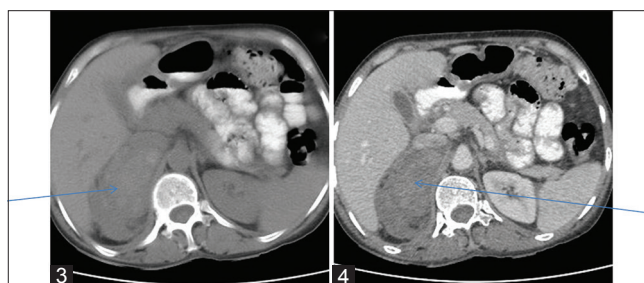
(3) Transverse section plain CT-enlarged right adrenal gland with ill-defined hyperintensities seen within the right adrenal gland. (4) Axial contrast-enhanced (CECT)-heterogeneous enhancement of right adrenal gland
